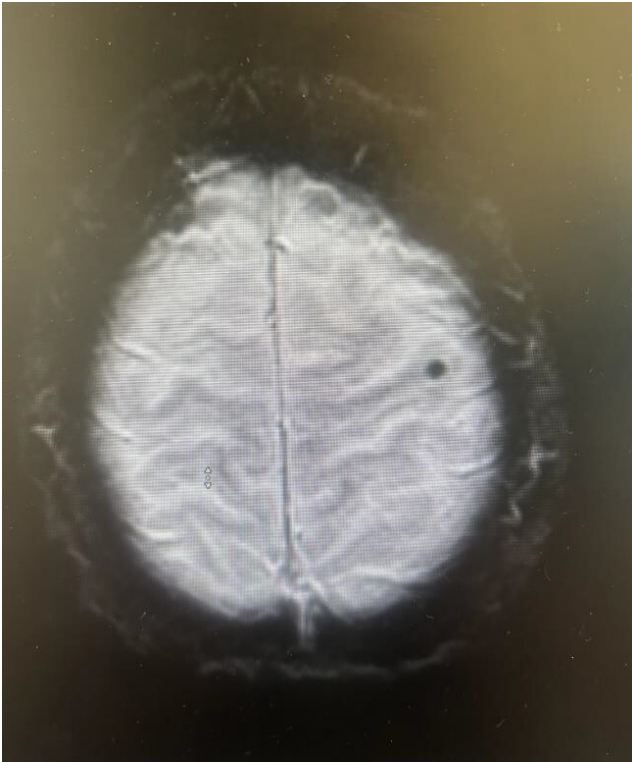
MRI W/ Contrast once again demonstrates a single tiny punctate calcification left high posterior frontal subcortical white matter without surrounding edema or enhancement
